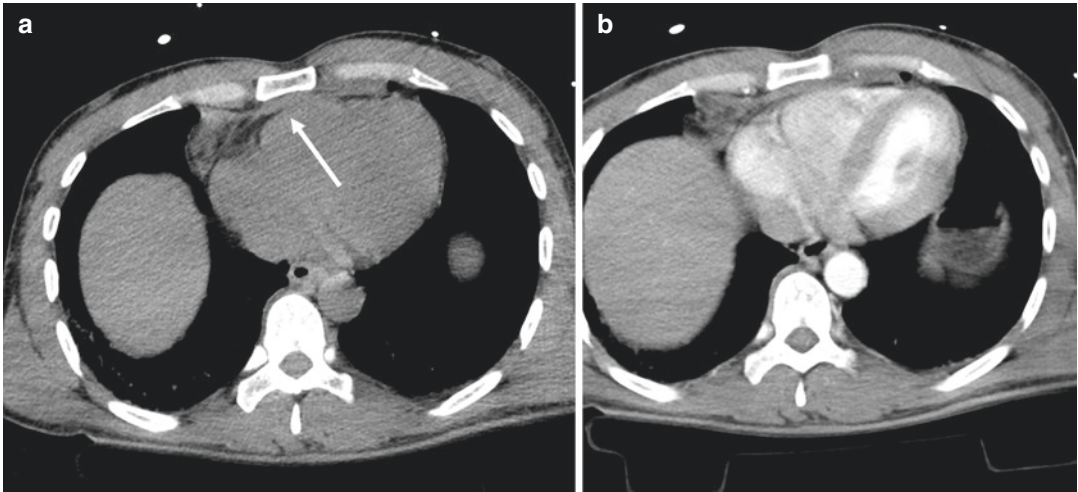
(a) Non-contrast enhanced CT shows a hyperdense pericardial effusion; this must be a warning sign (arrow). The CT study may require the completion of a
